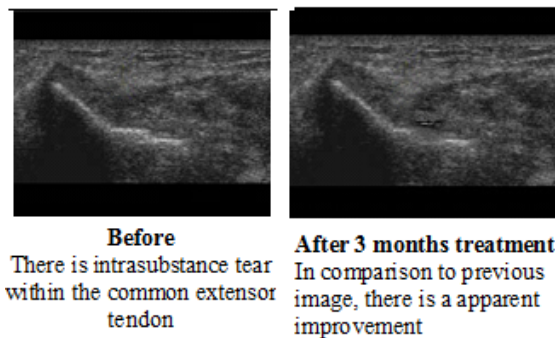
Musculoskeletal Ultrasound of right elbow 37 years old male patient with PRP injection
